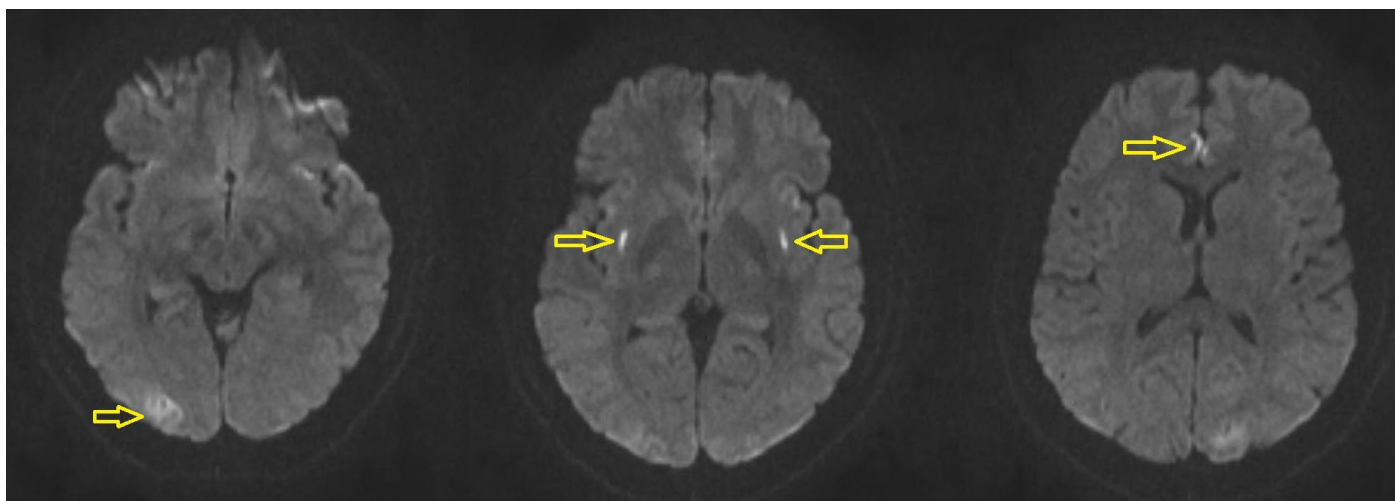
Diffusion MRI showing bilateral focal ischemia on the medial, frontal, parietooccipital, and perisylvian cortex.
